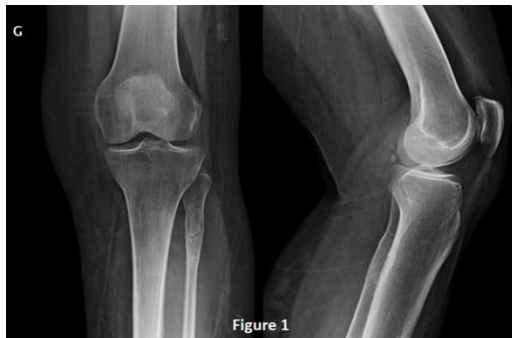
Standard AP and lateral X-ray with a lesional process of the upper extremity of the left fibula.
